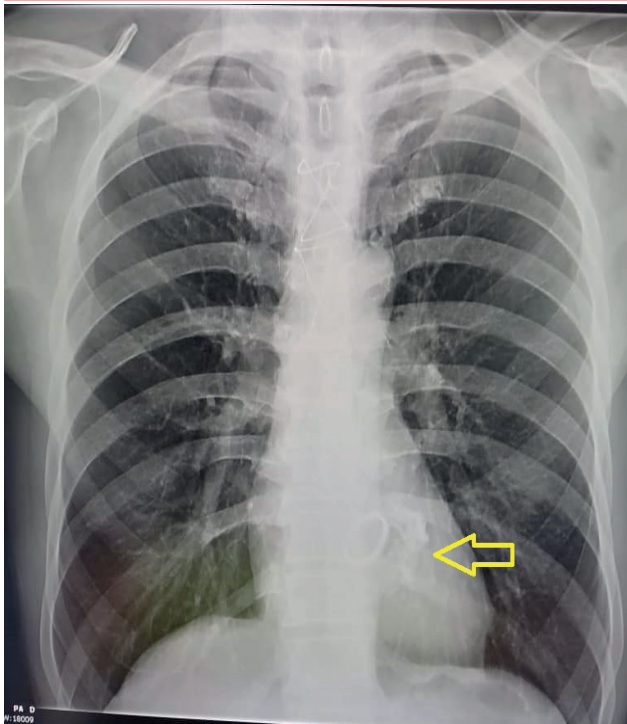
Chest X-ray in posteroanterior view. The yellow arrow indicates the coarse calcification contouring the mechanical prosthesis. It is located in the projection of the mitral valve apparatus, extending to the annulus and ventricular wall.
